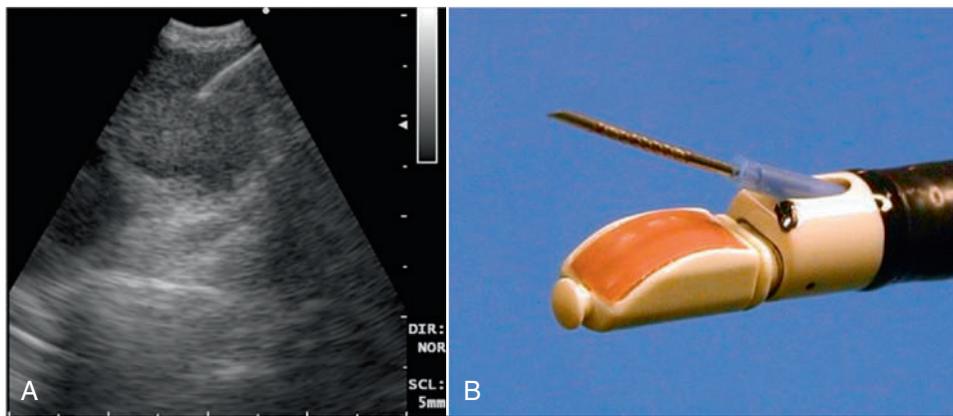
A, The distal tip of the endobronchial ultrasound endoscope with an aspiration needle. B, Sonographic image of EBUS-TBNA demonstrating needle inside lymph node. (B, From Medford AR: Diagnostic utility of endobronchial ultrasound-guided transbronchial needle aspiration for left paratracheal lesions. *QJM* 105[6]:589–590, 2012.)
